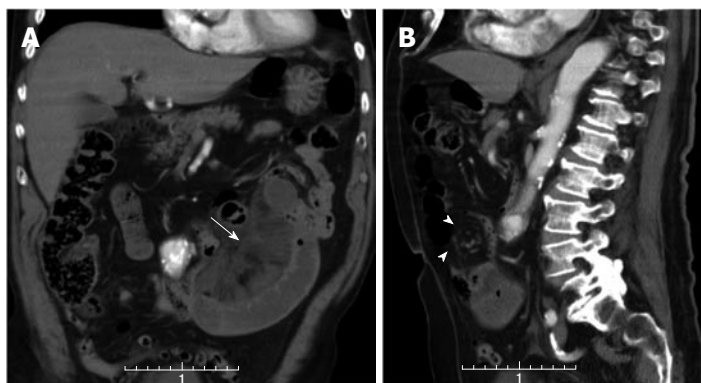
Multi-detector contrast-enhanced computed tomography. Coronal (A) and sagittal (B) reformatted 5 mm thick images are shown. In (A) a cluster of ischemic jejunal loops is depicted in the left flank along with mesenteric fluid (arrow). In (B) swirling of the mesenteric vessels (arrow-heads) is depicted. The computed tomography finding (whirl sign) was prospectively considered consistent with a small bowel volvulus which was not confirmed at surgery.
